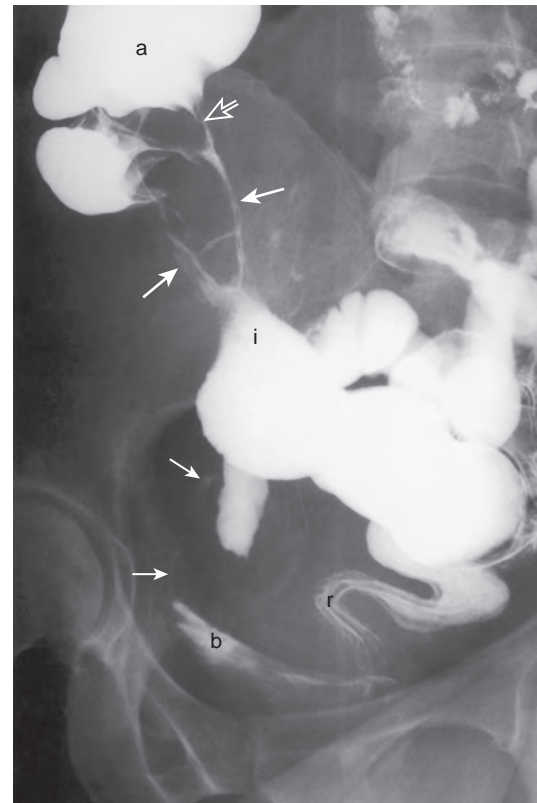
Multiple fistulas demonstrated on small bowel follow-through in a patient with Crohn's disease. An overhead radiograph obtained after barium reached the colon shows several tracks (*thick arrows*) coursing from the dilated distal ileum (*i*) to the ascending colon (*a*). One of these is a diseased terminal ileum and the other is an ileocolic fistula. Another fistula (*open arrow*) enters the medial wall of the ascending colon above the ileocecal valve. A thin, barium-etched fistula (*thin arrows*) courses from the ileum to the barium-filled urinary bladder (*b*). *r*, rectum.
